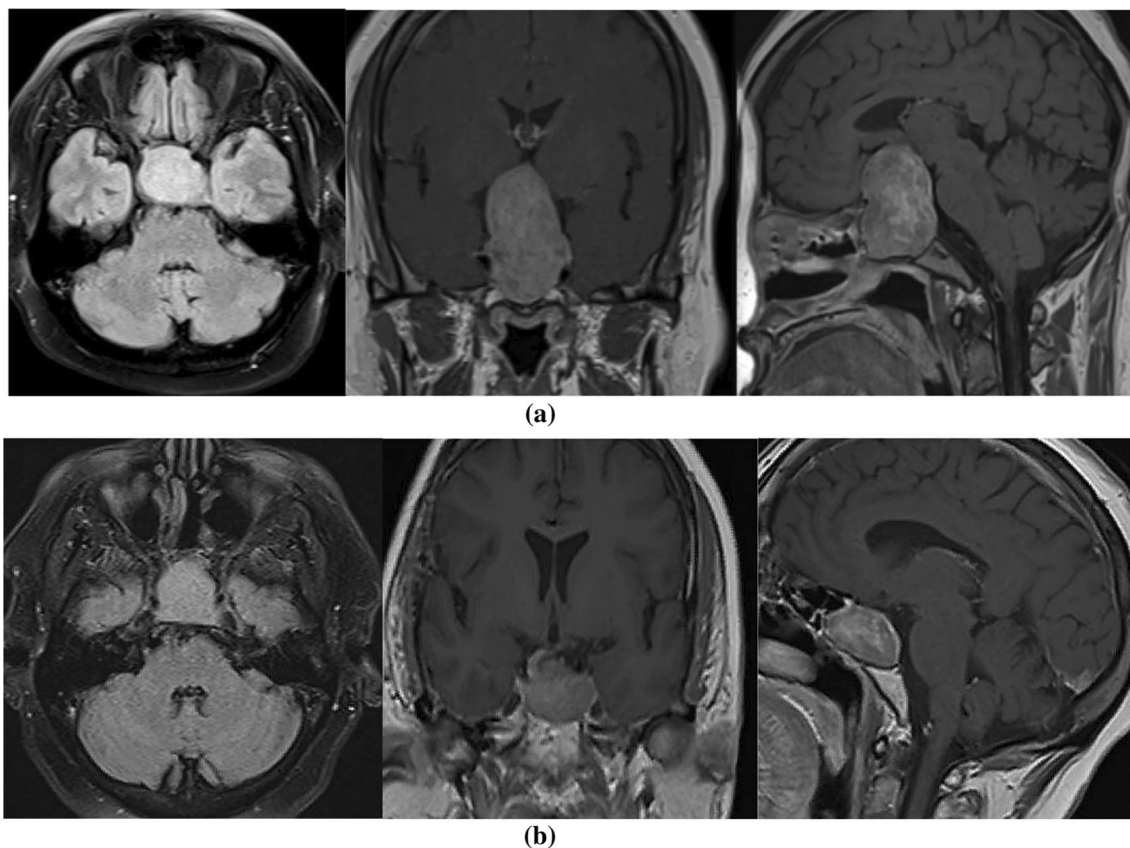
a A case of 50 years old female patient with giant pituitary adenoma underwent staged surgery (initial transsphenoidal surgery 3 years ago then presented with visual deterioration and planned for transcranial approach). b One month postoperative (extended pterional) MRI scan of the brain showing decompression of the optic chiasma
